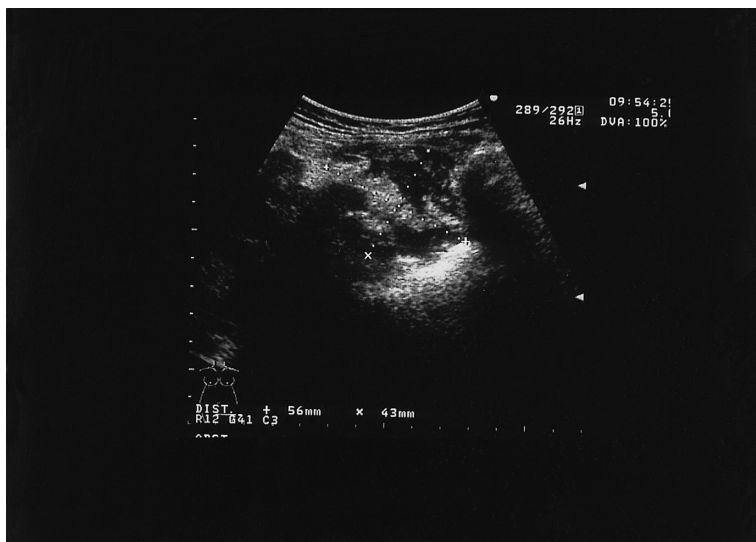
An ultrasound examination demonstrating the presence of an irregular mass measuring 70×50 mm in size
